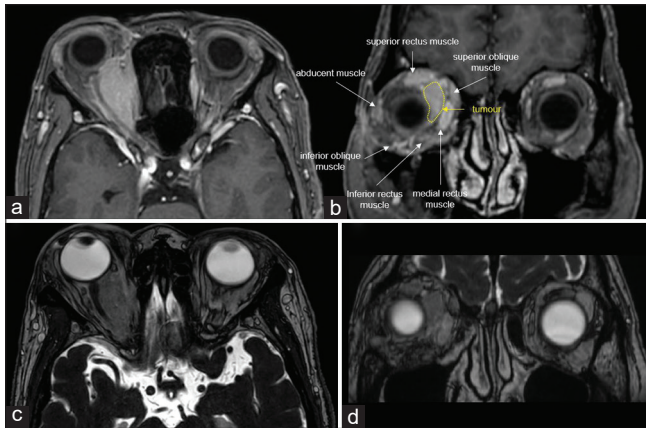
(a and b) T1-weighted Gd-enhanced magnetic resonance imaging showing a homogeneously enhanced lesion on the superior to medial side of the right orbit. (c and d) Constructive interference in steady-state sequence showing the internal rectus and superior oblique muscles compressed externally by the tumor.
